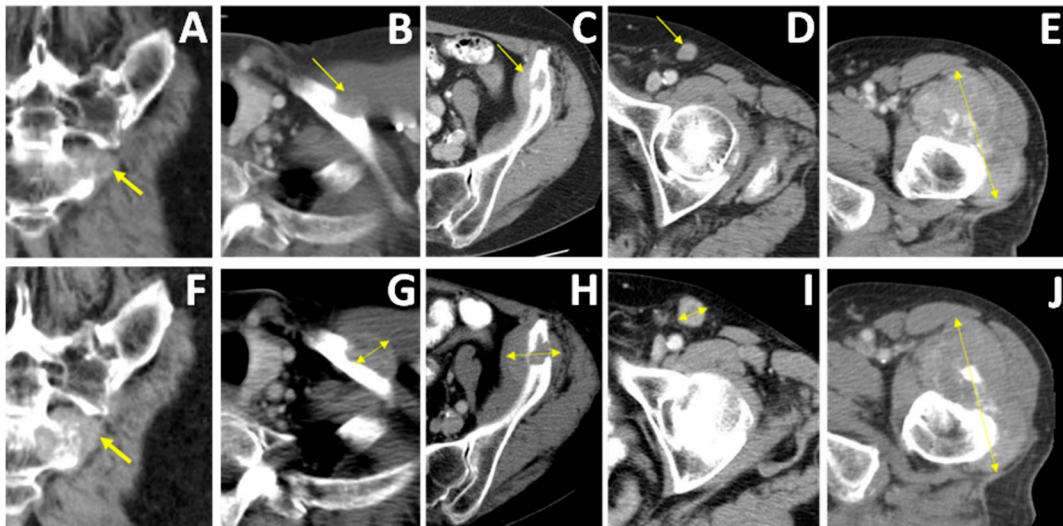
The progression of the lesions (yellow arrows) over time: contrast-enhanced CT axial sections, obtained at two consecutive time points (lower-row CT conducted 2 months after upper-row CT); left paramedian lower sacral mass at the level S4-S5, slight tumour growth (A+F); anterior shaft left clavicle (B+G); anterior part left iliac wing (C+H); left inguinal metastatic lymphadenopathy (D+I); index lesion of the proximal left femur (E+J); there is another focal left-sided iliac lymphadenopathy (not shown).
